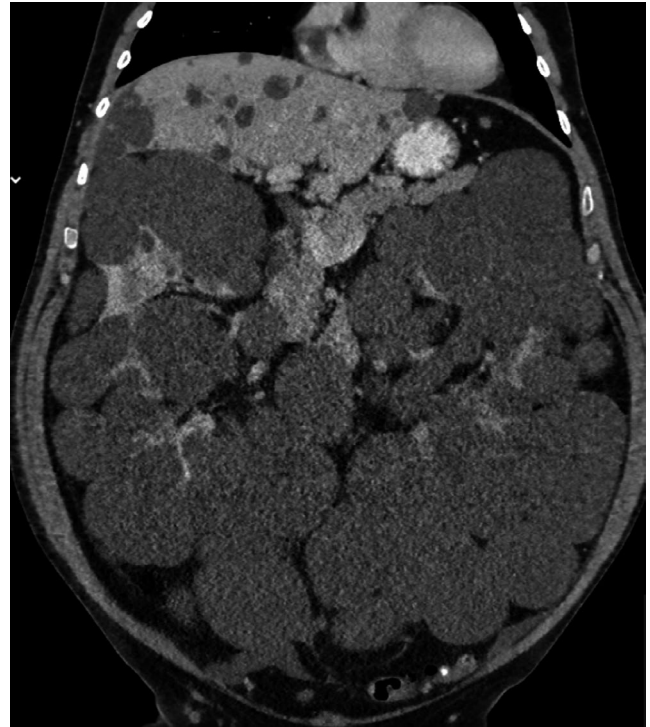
Bilateral kidney masses in coronal CT scan. Clinical question: In order to assess a possible indication for surgery, an overview of the topography of the abdominal conditions was needed. This shows that the abdomen is largely filled by the renal masses
